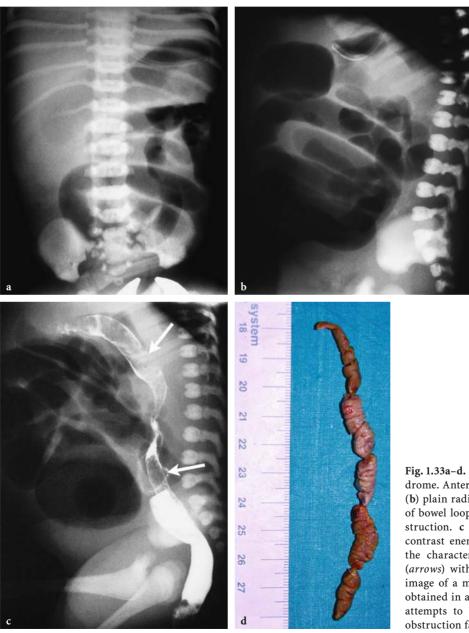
Meconium plug syndrome. Anteroposterior (a) and lateral (b) plain radiographs show distension of bowel loop consistent with low obstruction. c Isosmolar water-soluble contrast enema, lateral view outlines the characteristic long filling defect (*arrows*) within the colon. d Clinical image of a meconium plug surgically obtained in a patient in whom several attempts to conservatively solve the obstruction failed
